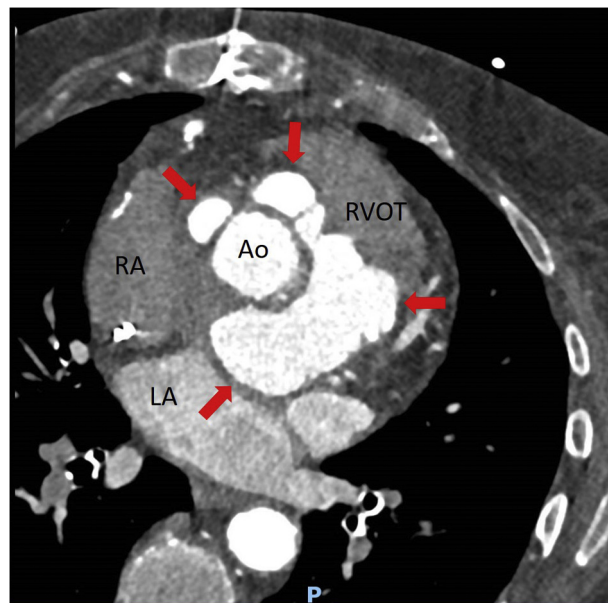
An axial slice from CTA above the level of the prosthetic aortic valve showing the proximal ascending aorta surrounded by the pseudoaneurysm cavity (red arrows). Ao, Aorta, LA, left atrium; RA, right atrium; RVOT, right ventricular outflow tract.
